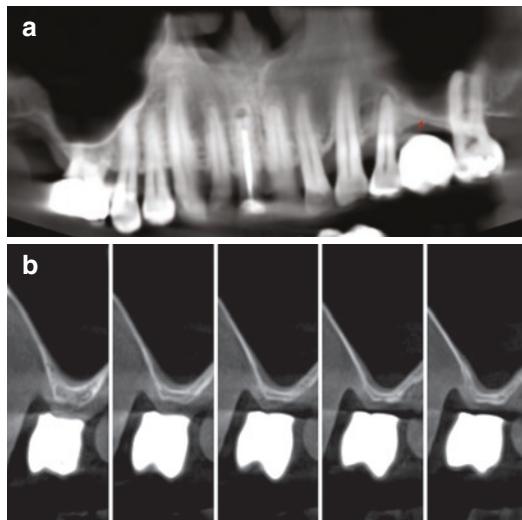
CBCT maxillary images produced for dental implant treatment planning with an opaque radiographic marker in the left posterior maxilla. (a) Reconstructed panoramic image. (b) Cross-sectional images. Pneumatization of the maxillary sinus is also visible in the region of interest (red arrow)
